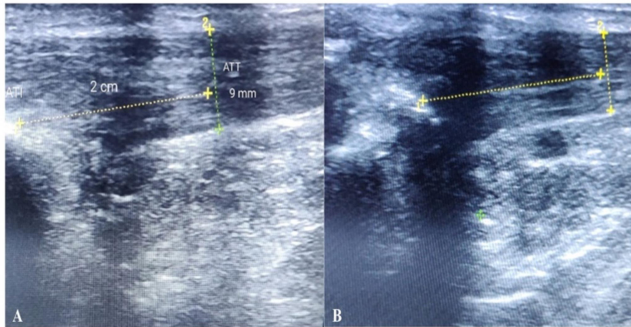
(A) Pre-op and (B) Post-op: Ultrasound for measurement of Achilles tendon thickness (ATT).
